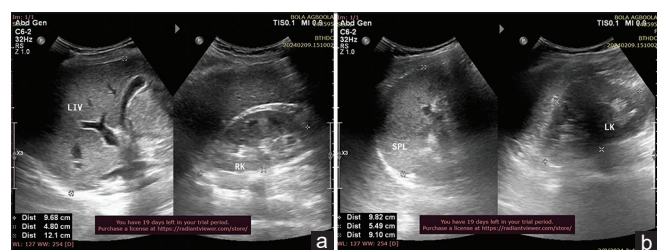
(a) B scan mode of ultrasound shows a normal-sized liver (12.1 cm in length) and right kidney (9.68 cm x 4.80 cm in length and anteroposterior [AP] diameters) in control adults. (b) B scan mode of ultrasound shows normal-sized spleen (9.82 cm in length) and left kidney (spans 9.10 cm x 5.49 cm in length and AP diameters) in control adults
